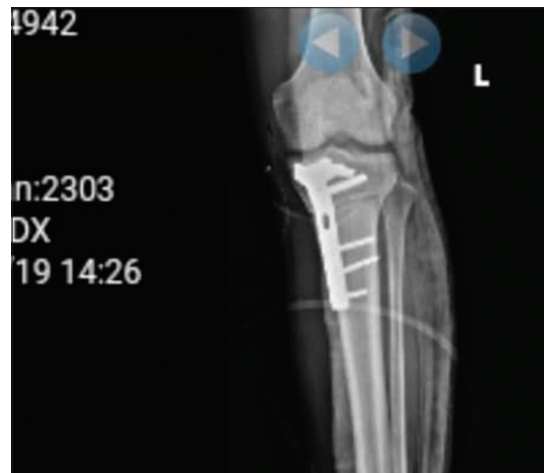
The postoperative radiography representing proximal varus deformity correction
